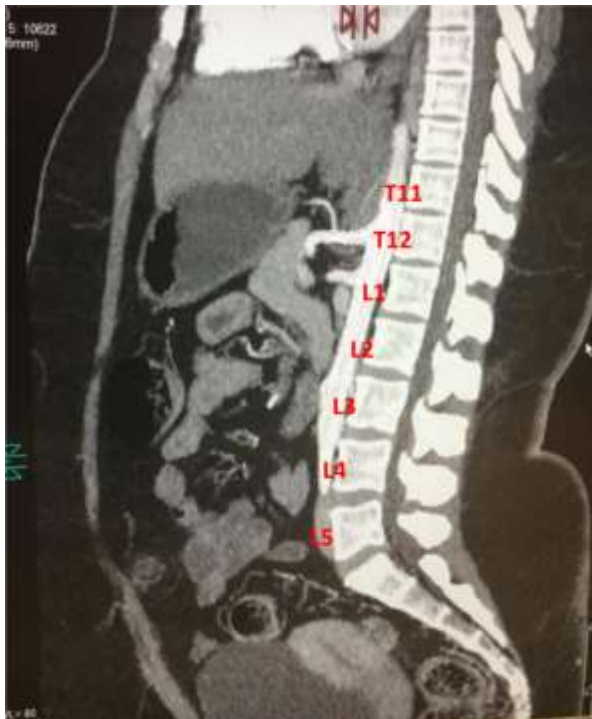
Showing MDCT scan (MPR) and (MIP) sagittal contrast CT enhanced image depicts T12 vertebra at which diameter of abdominal aorta was taken.
